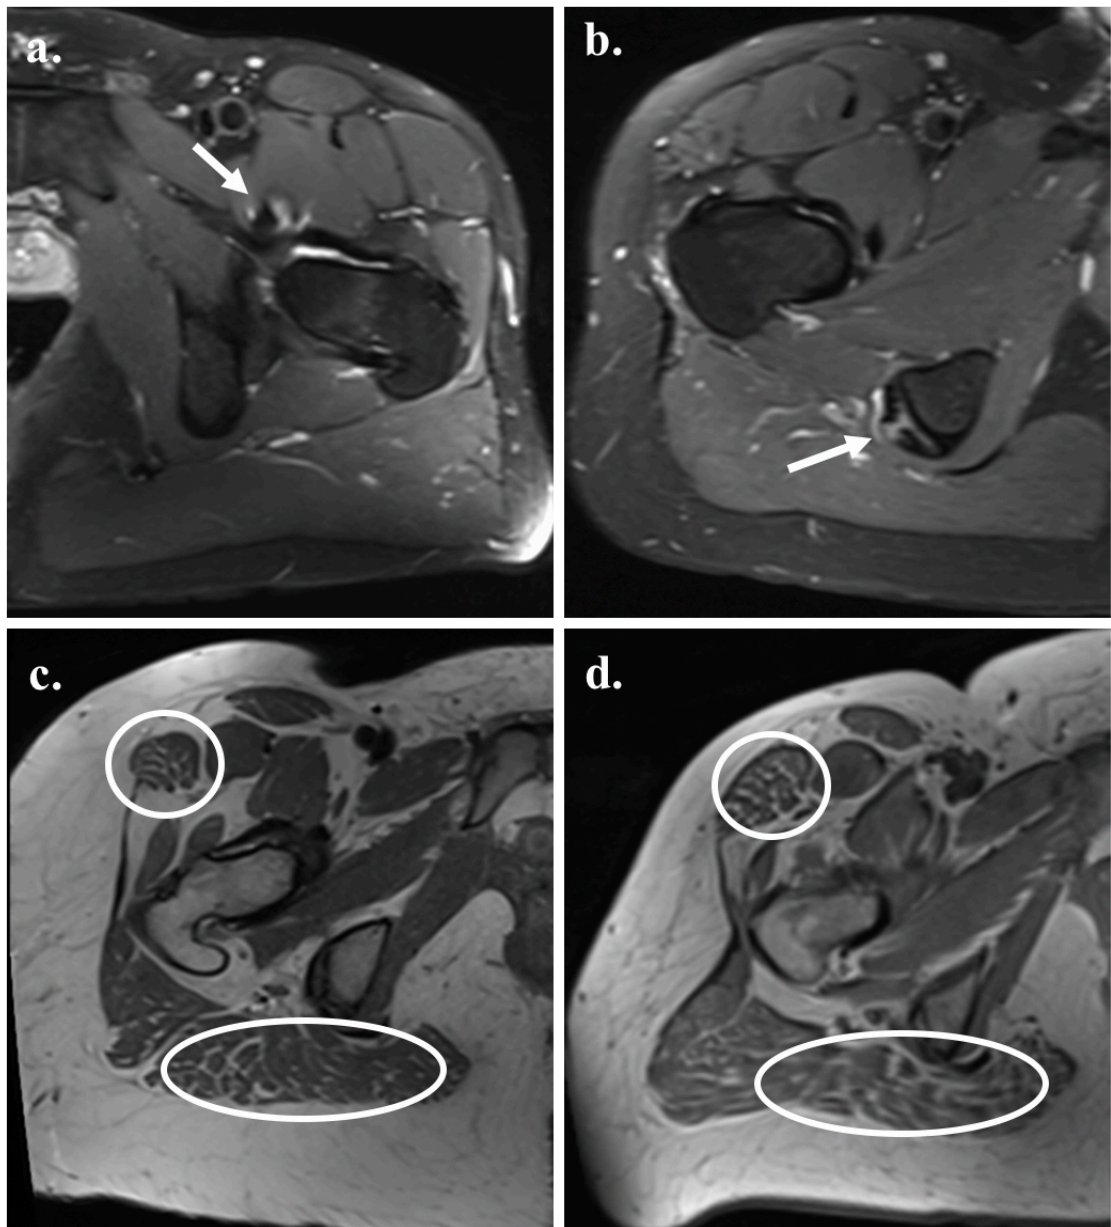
Axial Dixon MR images showing tendinosis, in ‘water phase’ sequences (a, b) and fatty muscle atrophy, in ‘in phase’ sequences (c, d), in 4 runners, respectively: a) Non-marathoner 1 with psoas tendinosis (arrow); b) Marathoner+ 1 with hamstring tendinosis (arrow); c) Non-marathoner 2 with gluteus maximus mild atrophy (big oval) and tensor fascia latae mild atrophy (small circle); d) Marathoner+ 2 with gluteus maximus mild to moderate atrophy (big oval) and tensor fascia latae mild atrophy (small circle). The grading systems developed by Chi *et al* [261] and Goutallier *et al* [262] were used in the assessment of tendons and muscles, respectively.
